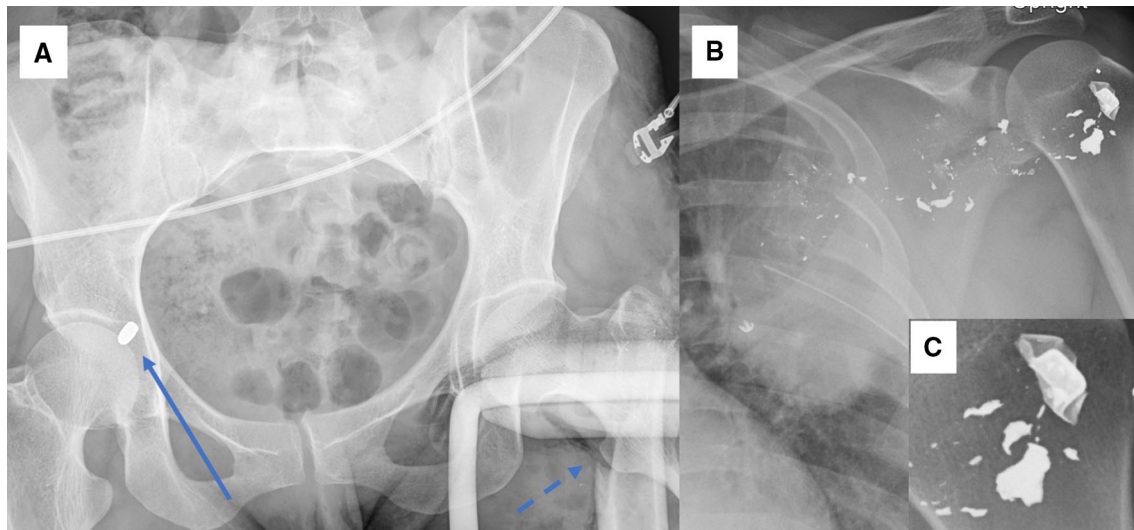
Bullet identification: Panel A demonstrates a full metal jacketed bullet (solid arrow) that has shattered the left femur but itself remained intact. Panel B demonstrates a transthoracic gunshot wound with semi-jacketed bullet note the pulmonary contusion, the scapular fracture and final resting place of the bullet suggest a front to
